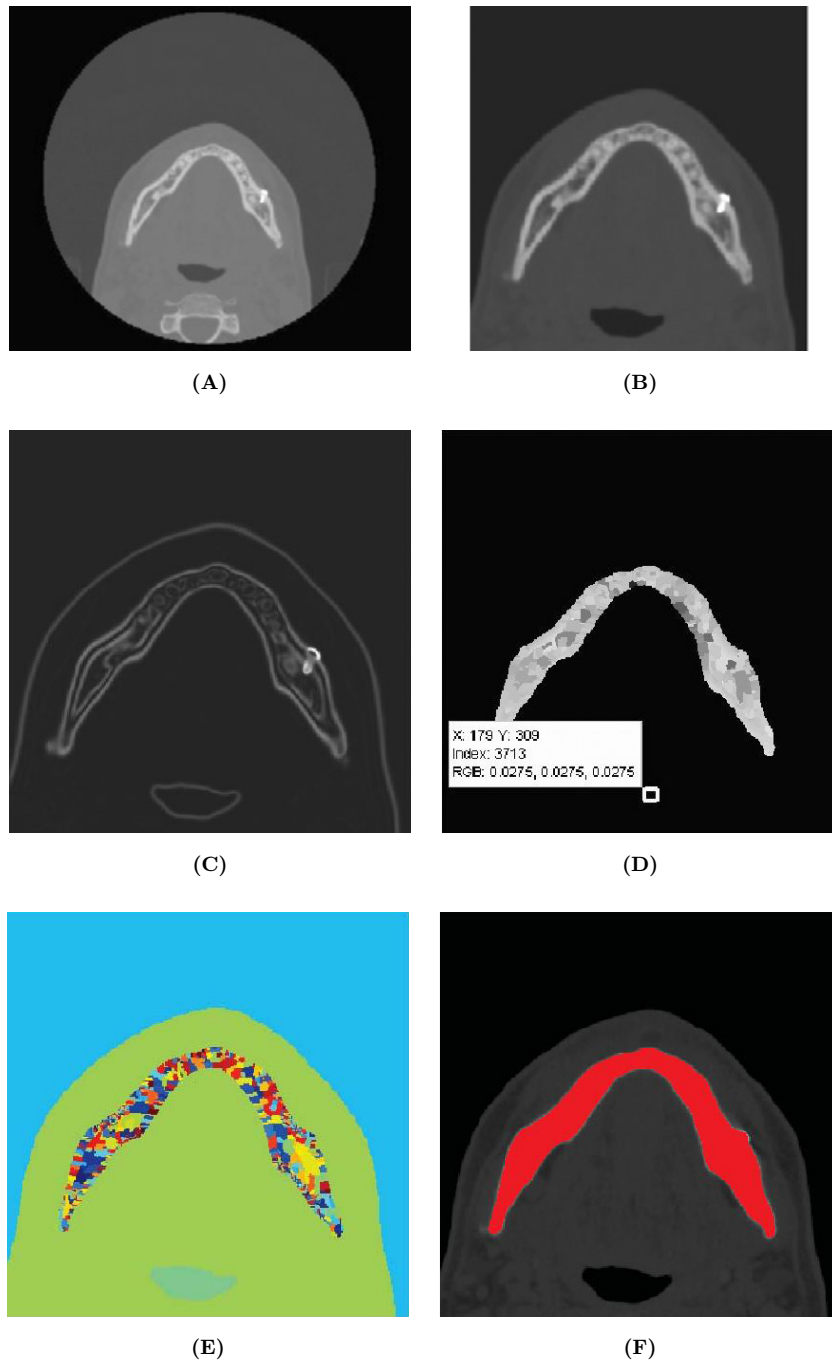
Jaw bone preprocessing and segmentation. (A) CT skull axial slice view. (B) ROI with noise reduction through the anisotropic diffusion filter. (C) Image Gradient module of B. (D) Watershed segmentation applied to border image C. (E) Watershed image view on color map. (F) Jaw zone selection through threshold technique.
